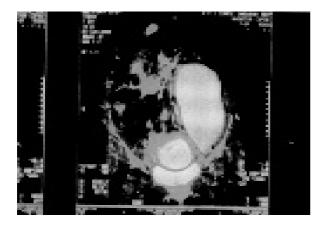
MRI showing largeleft psoasabscess and intraspinal pus and granulation tissue.
